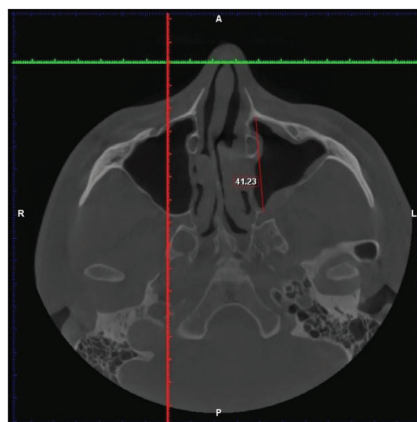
Anteroposterior dimension of the maxillary sinus on axial projection of cone-beam computed tomography
